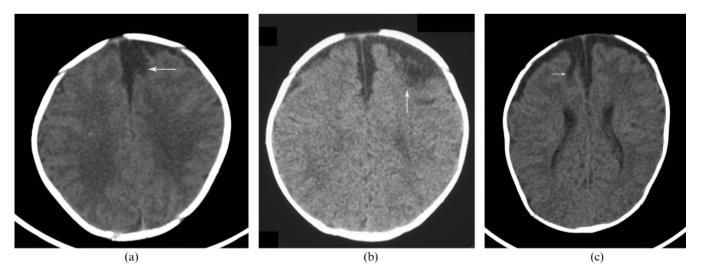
CT appearances of cortical tears. (a) Case 1. Cortical tear in the left superior frontal gyrus. There is deep white matter of high attenuation in the right centrum semiovale, which may represent either calcification or haemorrhagic change. (b) Case 2. Cortical tear in the left superior frontal gyrus with local cerebral atrophy. (c) Case 4. Cortical tear in right superior frontal gyrus.
